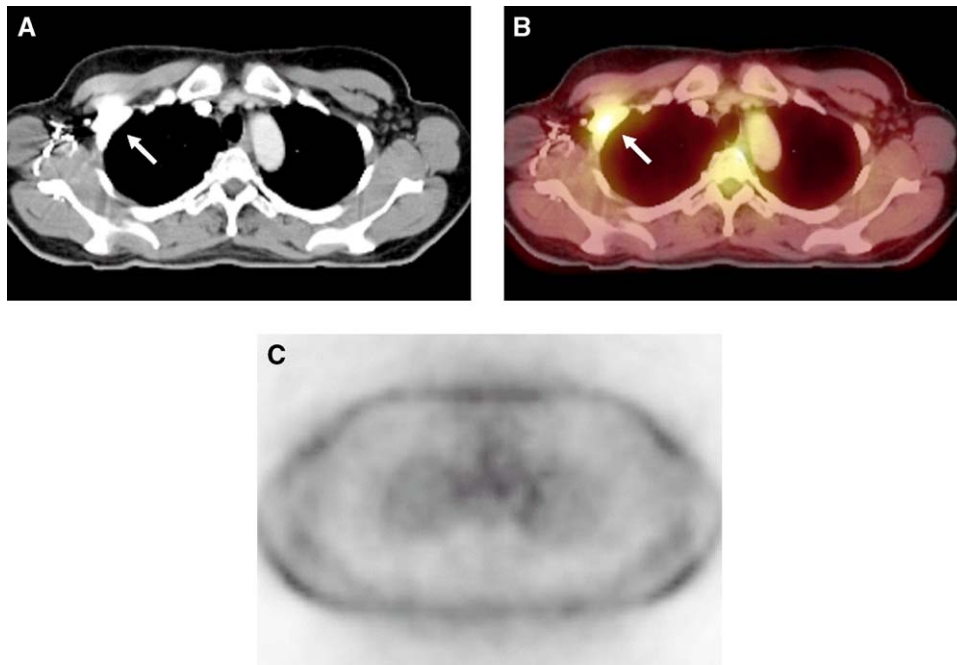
High-density artifacts in subclavian vein of a patient after bolus IV contrast injection with CT scanning in the cranio-caudal direction. The CT artifacts (A) translate into an artificial tracer uptake in the corrected PET (B), but cannot be seen on the noncorrected emission images (C).
